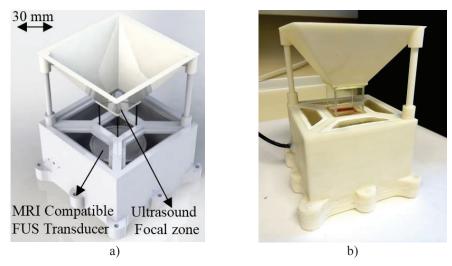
a) Design for the MRI-Compatible HIFU chamber, b) The lab- manufactured chamber as per the design.
